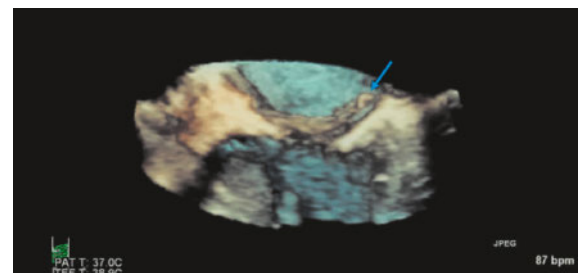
3D-transoesophageal echocardiography with 3D-zoom on the mitral valve. Acute mitral regurgitation due to flail leaflet after an acute inferior myocardial infarction. There is a piece of papillary muscle attached to the chordae (arrow).
